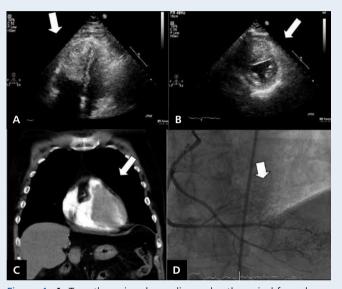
A. Transthoracic echocardiography, the apical four-chamber view showed a large tumour involving the right ventricle, measuring about 6×4 cm² (arrow); B. Transthoracic echocardiography, the parasternal short axis view showed tumour compression over the ventricular septum and left ventricle with D-shape (arrow); C. Computed tomography of the chest with contrast-media demonstrated a large tumour lesion (9.4 cm, arrow) involving the right ventricle and the root of the pulmonary trunk; D. Coronary angiography revealed tumour blush (arrow) from the left descending artery-septal perforator and right coronary artery
